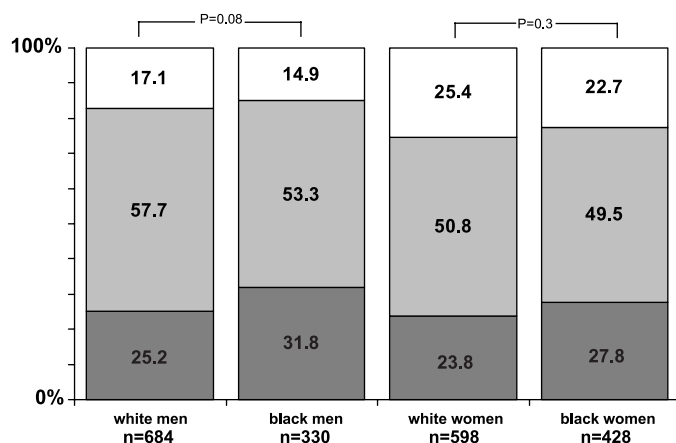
Prevalence of 2-yr change in appendicular lean soft tissue mass (ALST) as measured by dual-energy X-ray absorptiometry in the Health, Aging, and Body Composition Study. Values are percentages;  $n$ , no. of subjects. Black bars, loss >3%; gray bars, stable; open bars, gain >3%. Differences by race were tested by using the  $\chi^2$  test.
